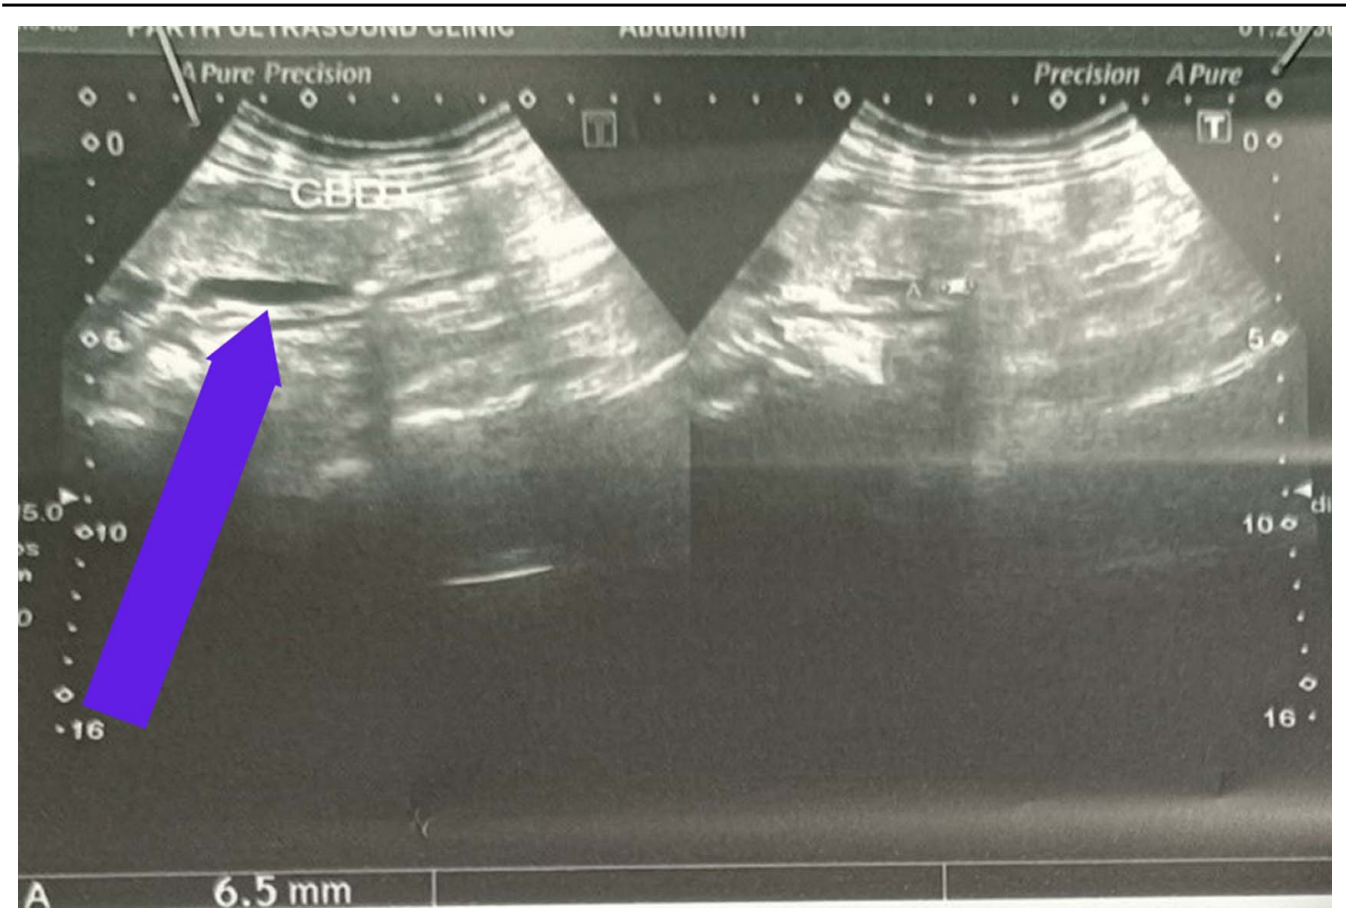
Ultrasonography showing dilated CBD with bile duct stone (blue arrow). CBD, common bile duct.
